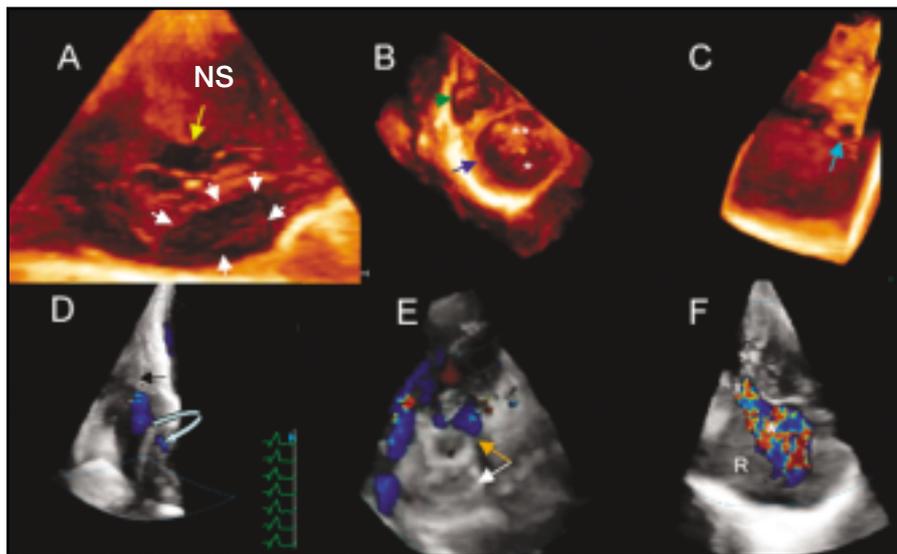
Three-dimensional echocardiographic images obtained with Philips Sonos 7500 showing ventricular septal defect (yellow arrow) and atrial septal defect (white arrows) seen from left ventricular cavity (A); short axis view from LA and RA showing mitral (blue arrow) and tricuspid annuli (green arrow) and myxomatous anterior (double white asterisk) and posterior mitral valve leaflets (single white asterisks) and mitral valve prolapse (B); orifice of patent foramen ovale shown on color Doppler in the next panel (light blue arrow) from right atrium (C); pacing catheter in RV (black arrow) and color Doppler showing flow across PFO (curved arrows) (D); right (orange arrow) and left (white arrow) atrial discs of Amplatzer device and small degree of left to right through the central orifice of RA disc in a patient post-percutaneous closure of atrial septal defect (E); tricuspid regurgitation jet (white asterisk) in RV inflow view and tricuspid regurgitation jet (white arrow) by 3D color Doppler (F). RA, right atrium; RV, right ventricle.
